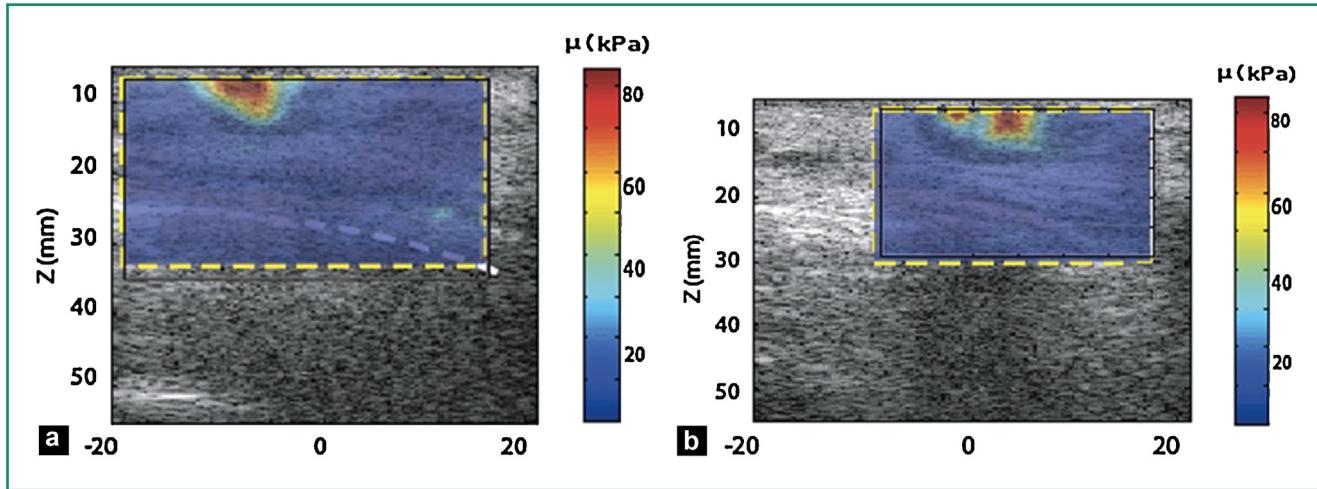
a: breast elastography. An adenocarcinoma appears stiffer in the elasticity image and darker in the ultrasound image; b: second elasticity image of the same lesion [25].
